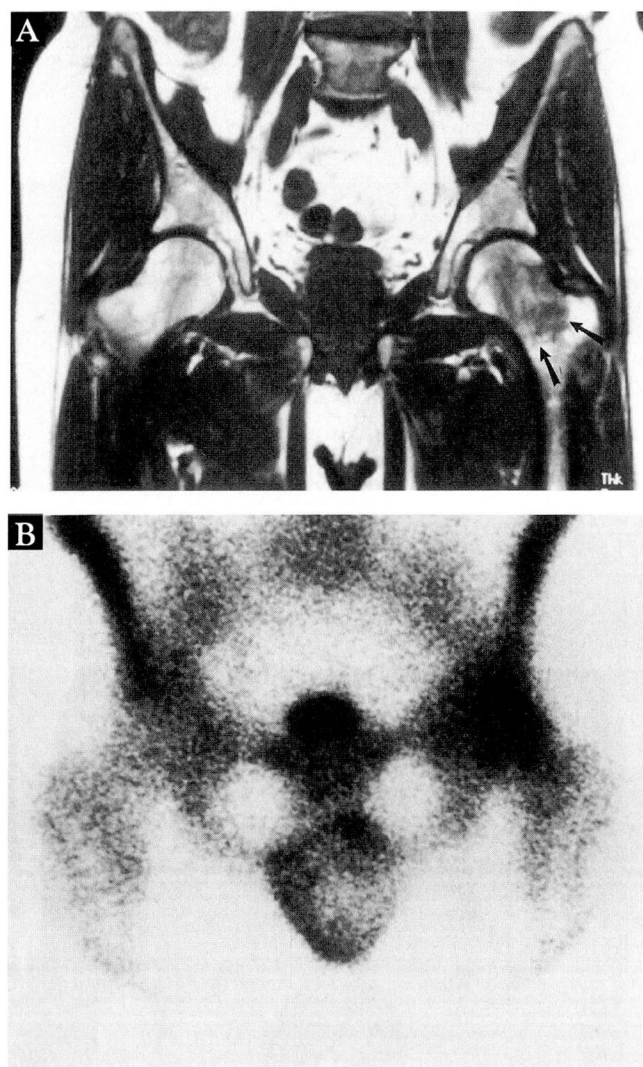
A 63-year-old man with transient osteoporosis of the left hip. Coronal T1-weighted magnetic resonance image of the pelvis (A) shows decreased signal intensity relative to normal bone marrow, extending from the femoral head into the intertrochanteric region (arrows). A ^{99m}Tc methylene diphosphonate scan (B) shows increased uptake in the same area.
